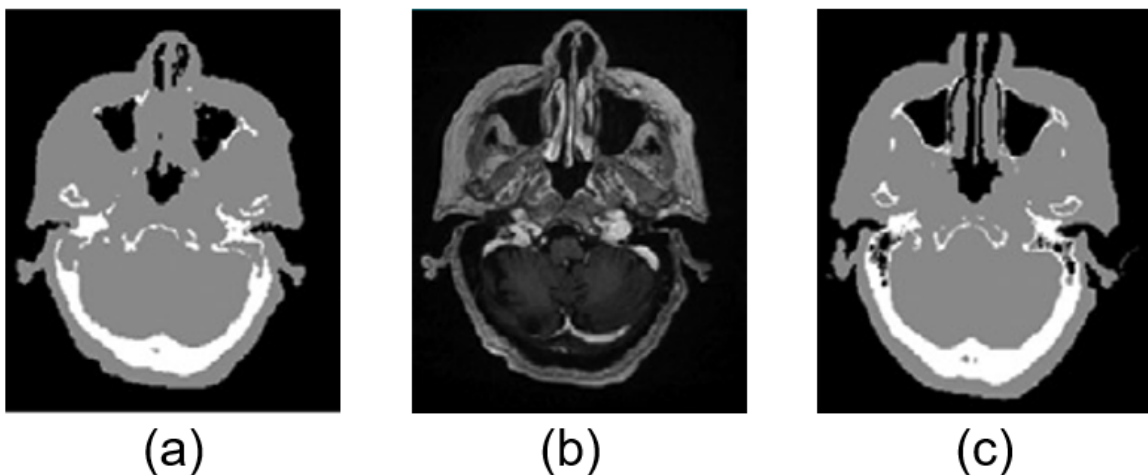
Pseudo CT image (a) obtained by segmenting T1-w MR image (b) with the use of CT image (c) as a reference mask [103].
